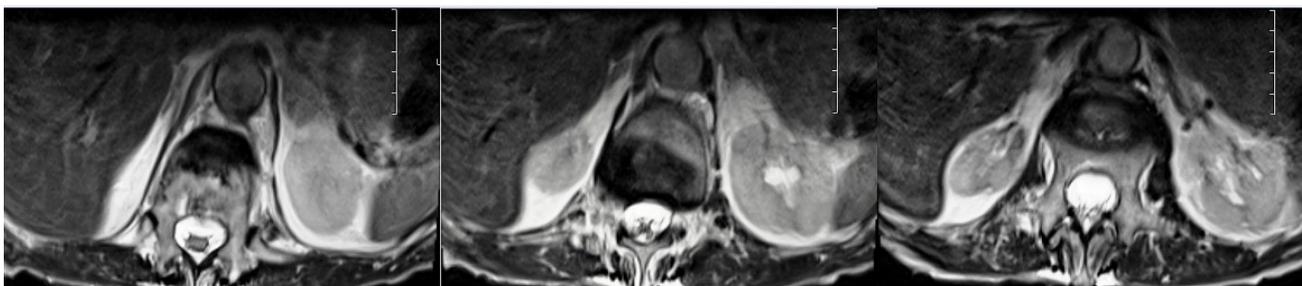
MRI of lumbar spine done for evaluation of severe back pain showing T2 signal surrounding the distal aorta. The aortal appears to be enlarged with suspicion of mycotic aneurysm
